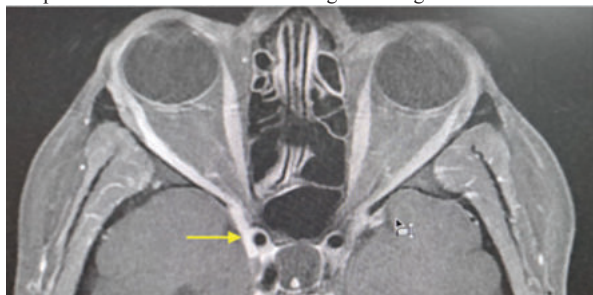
T1 weighted post-contrast MRI image of the brain with orbit demonstrating intense abnormal linear dural enhancement (yellow arrow) along the superior orbital fissure extending into the lateral wall of the anterior part of the right cavernous sinus.
